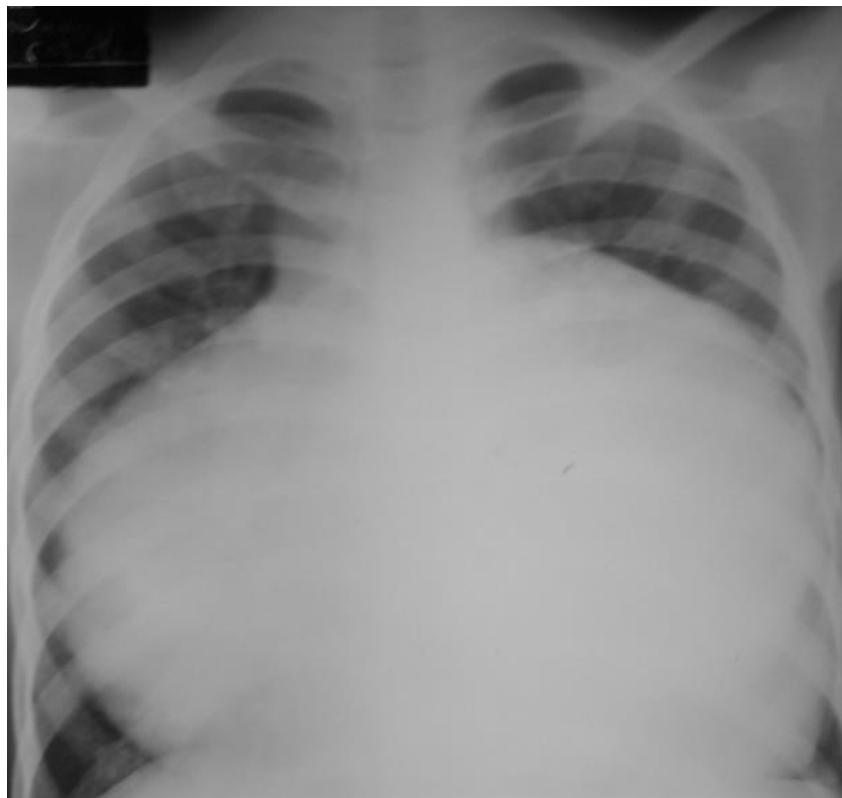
Chest radiograph in a patient with cardiomegaly secondary to pericardial effusion. Note the sharp cardiac margins, globular shape of the heart and paucity of peripheral vessel markings.
